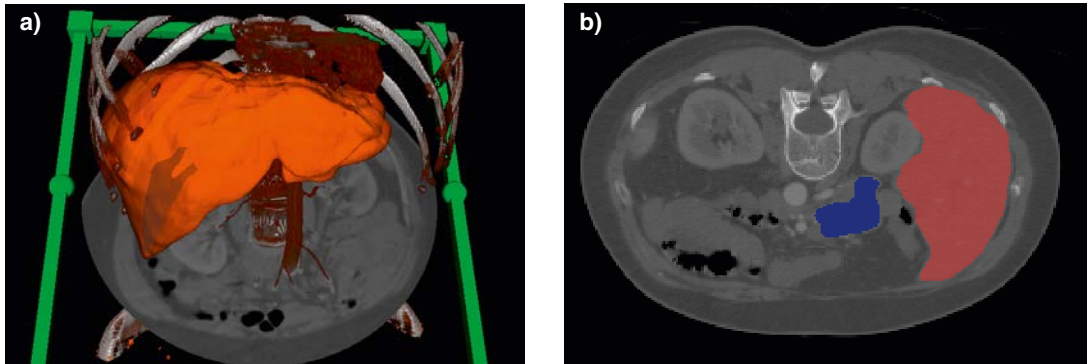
Liver segmentation example: (a) DVR emphasizing bones combined with isosurface rendering of the segmented liver and cutting plane showing original CT data. (b) 2D view of the same dataset with segmented liver in red and constraints in blue.
